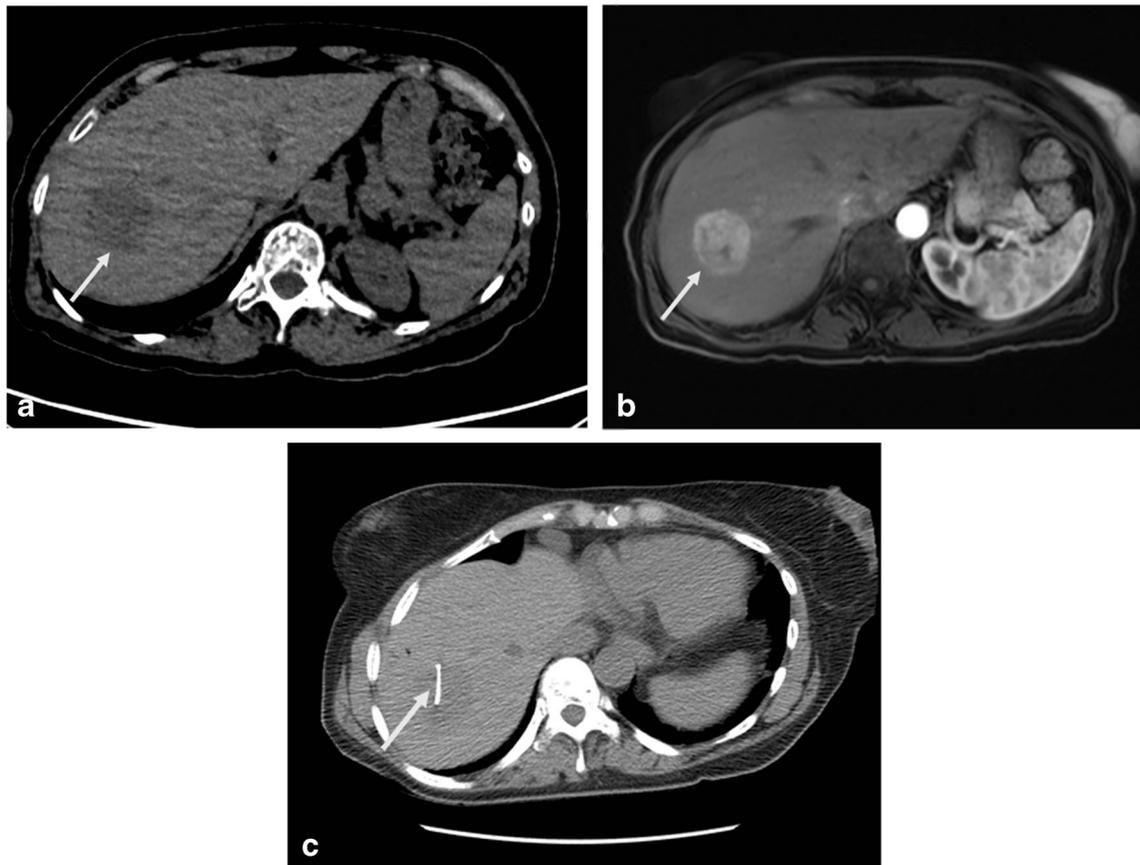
A 63-year-old woman with multiple myeloma and an incidentally found hepatocellular carcinoma. a Axial CT image from WBCT demonstrates a low attenuation mass in the right lobe of the liver (*arrow*). b
